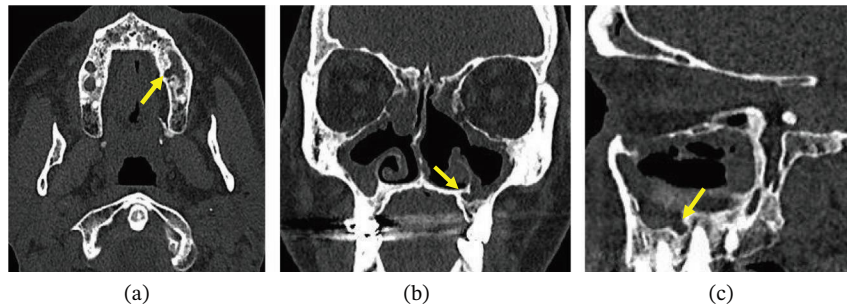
Cone-beam computed tomography (CBCT) images in (a) axial, (b) coronal, and (c) sagittal planes. The yellow arrows highlight the alveolar recess. The images demonstrate anatomical continuity with the sinus cavity, thereby confirming its nonpathological nature and ruling out a cystic lesion.
